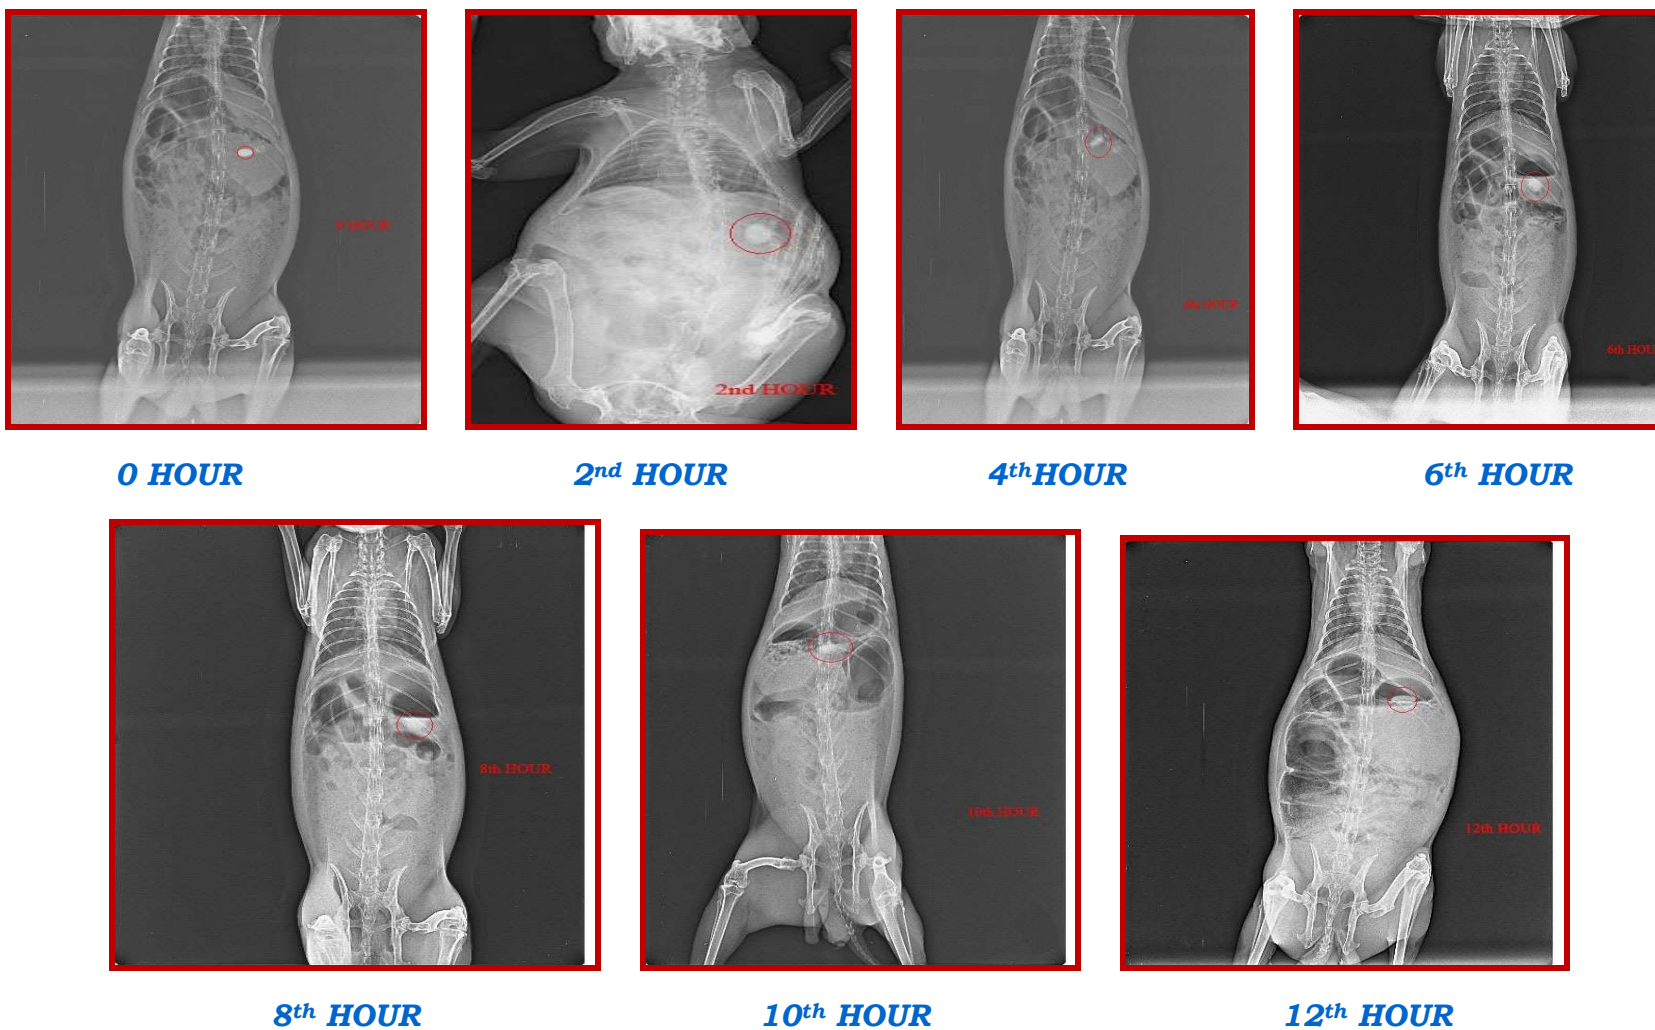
IN VIVO* X-RAY PHOTOGRAPHS OF VALSARTAN FLOATING MATRIX TABLET (BEST FORMULATION)
